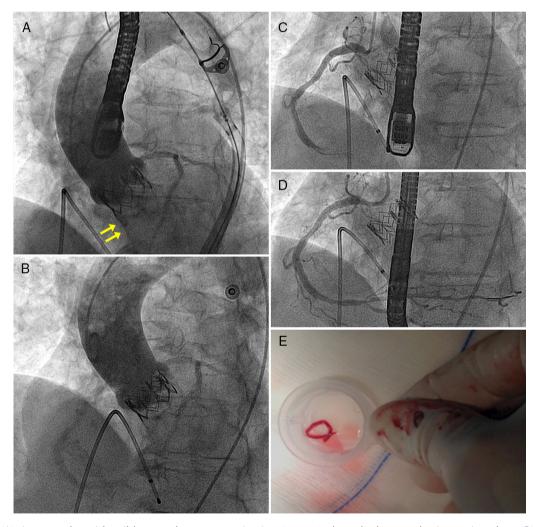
(A) Aortography with mild to moderate regurgitation (arrows) through the prosthetic aortic valve; (B) aortography showing resolution of regurgitation after removal of thrombus from the right coronary artery (CA) (due to immediate improvement of left ventricular function seen on transesophageal echocardiography); (C) acute thrombotic occlusion in the mid third of the RCA; (D) RCA with TIMI 3 flow after extraction of the thrombus; (E) thrombus extracted from the RCA after aspiration with the Pronto device.
